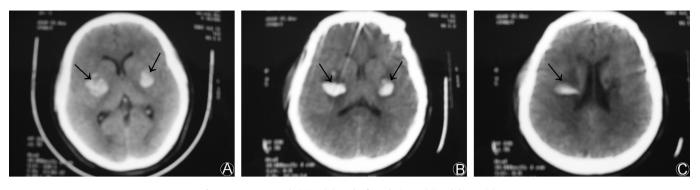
CT images at admission (A), 48 h after admission (B) and day 21 (C).
